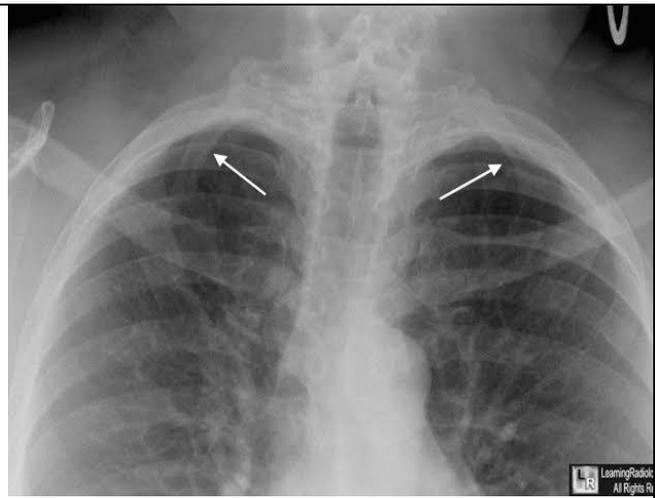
AP chest X-ray with bilateral cervical rib (white arrow)
